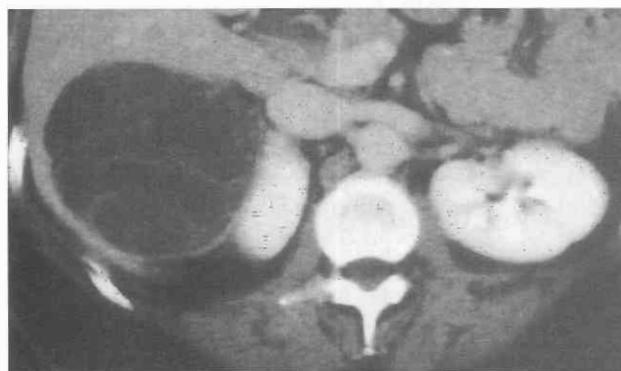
Multilocular cystic renal cell carcinoma; category III lesion. A contrast-enhanced CT scan reveals a well-defined, mainly fluid-containing mass in the right kidney. Enhancing septa are seen throughout the lesion. A right nephrectomy was performed.
